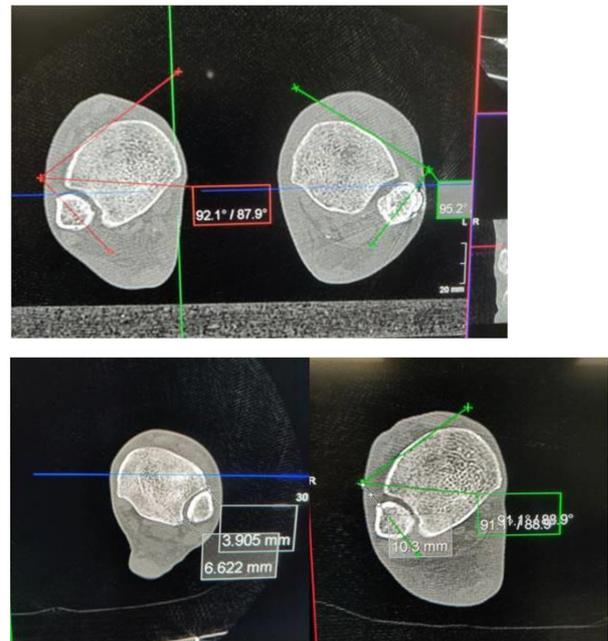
Photograph of the measurement of the anterior tibiofibular distance (ATFD), posterior tibiofibular distance (PTFD), and anteroposterior fibular translation (APFT); and the angle of fibular rotation (AFR) in the CT (computed tomography) scan.
